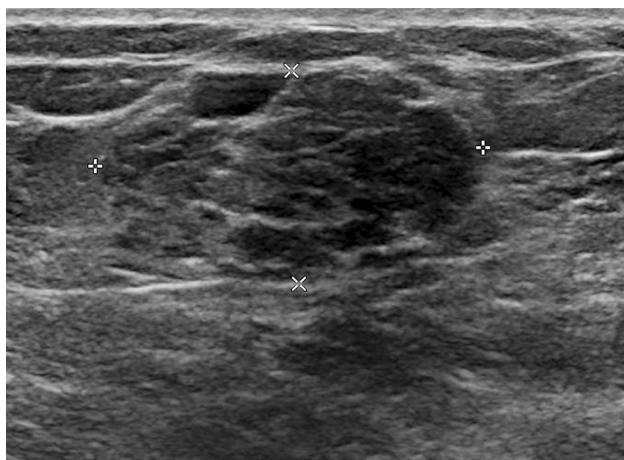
A 45-year-old postpartum female with a palpable left breast lump. Targeted ultrasound demonstrates a corresponding complex solid and cystic mass. Ultrasound-guided core biopsy was recommended and pathology returned benign lactating adenoma
